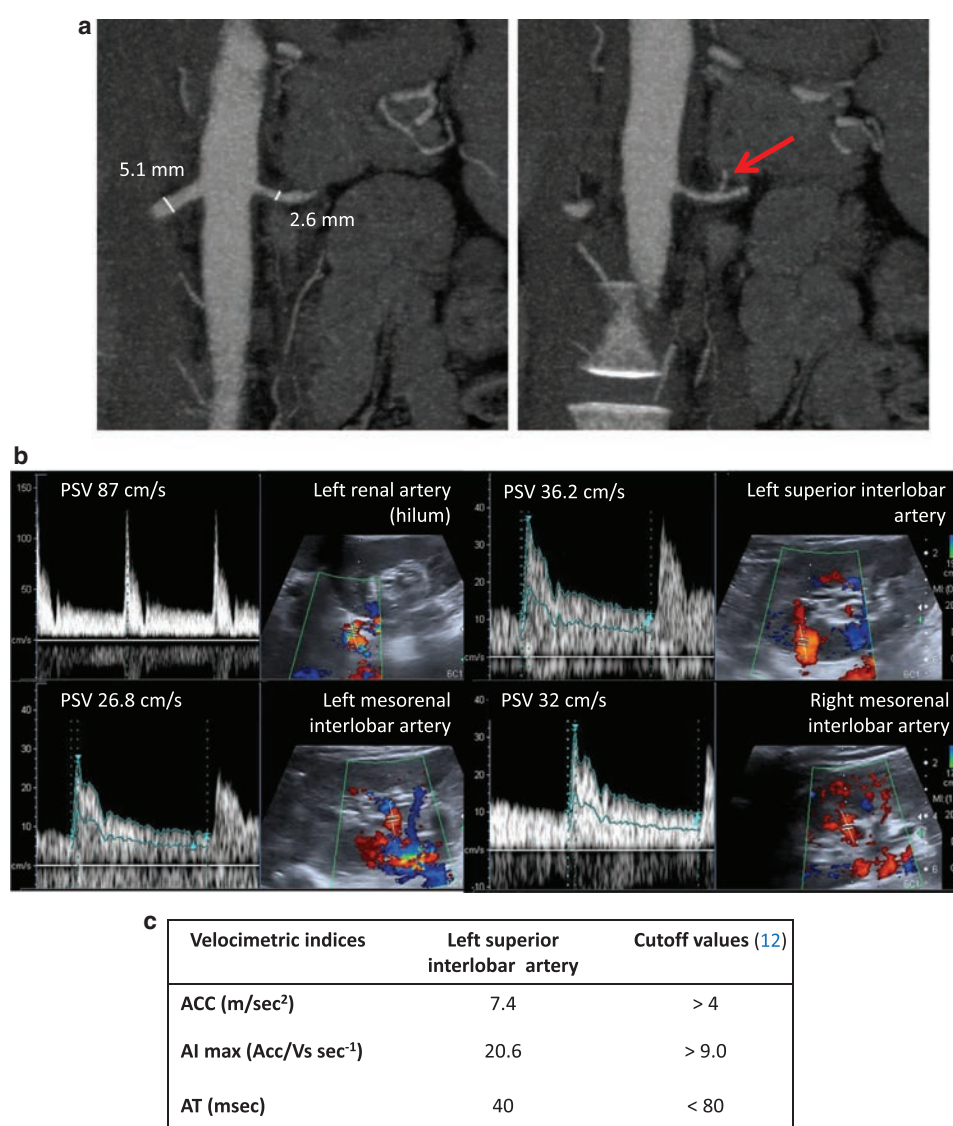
a) Abdomen CT scan image. The red arrow indicates the suspected left renal artery stenosis. b) Renal echocolor Doppler images and velocimetric indices. PSV, peak systolic velocity; ACC, maximal systolic acceleration, AI_{max}, maximal acceleration index; AT, acceleration time.
